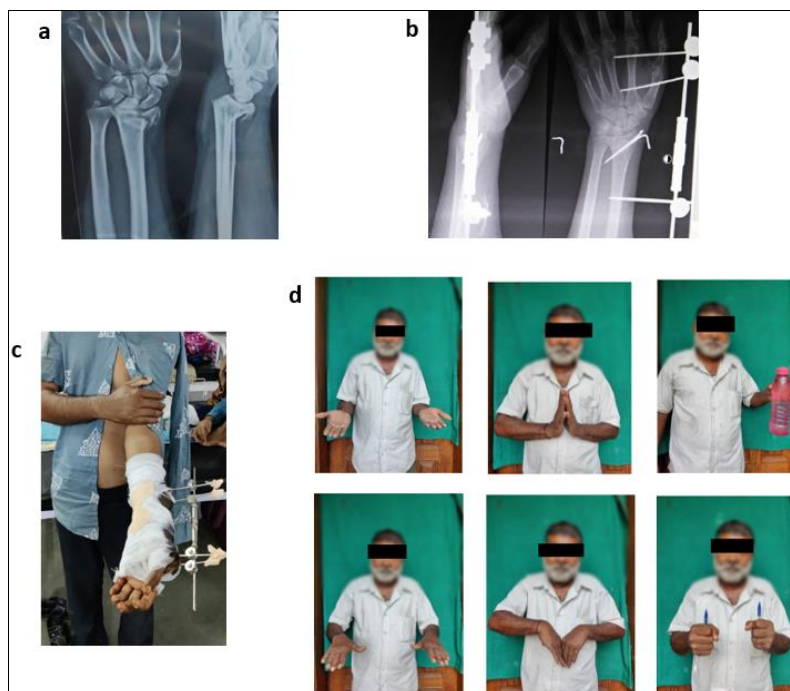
Case 5: a. Pre-operative X-Rays. b. Post-operative X-Rays. c. Post-operative clinical photo. d. Supination, Dorsi Flexion and Grip Strength (Up, left to right), Pronation, Palmer Flexion and Grip Strength (Down, left to right)
